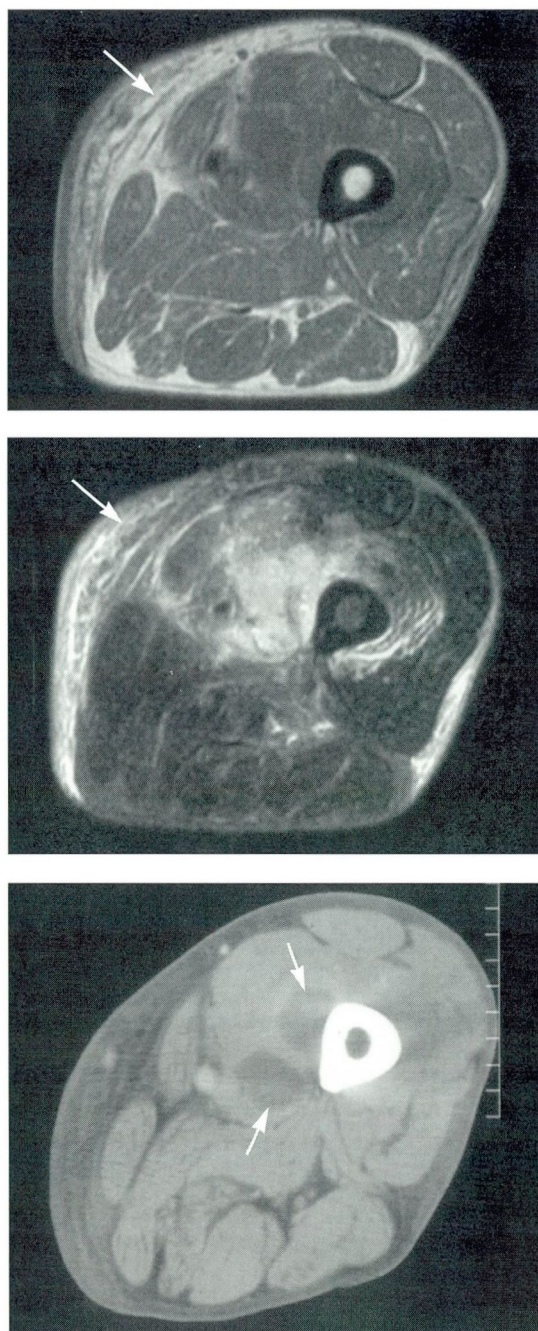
Magnetic resonance imaging (MRI) and computed tomographic (CT) studies of the patient's thigh, demonstrating the clinical progression of pyomyositis. T1-weighted MRI (top) and T2-weighted MRI (middle) demonstrate diffuse inflammation (bright, increased signal on T2) without focal abscess. Bottom, CT scan the next day shows a hypodense abscess (pyomyositis) medial to the femur.
